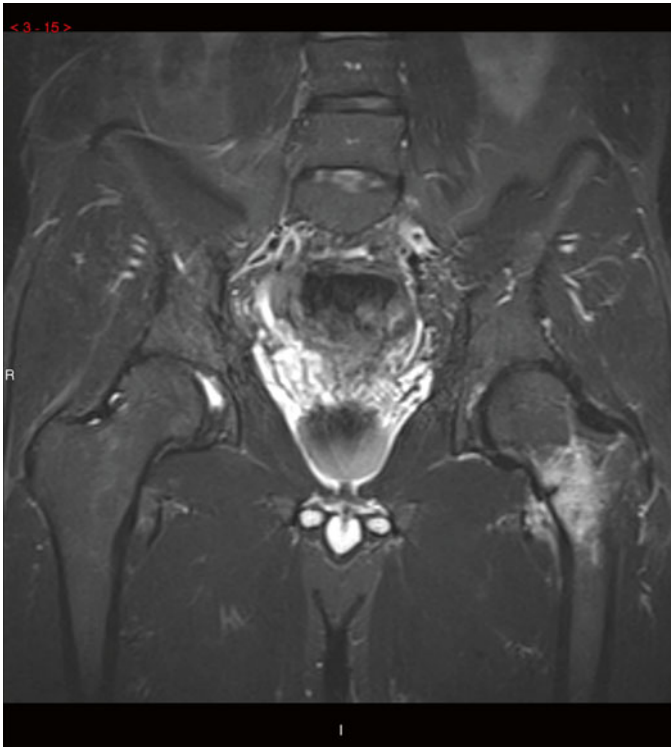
Coronal STIR sequence MRI showing marked left femoral neck bone edema (*white*) with inferior femoral neck cortical disruption (*black line*) typical of a compression-side stress fracture.
